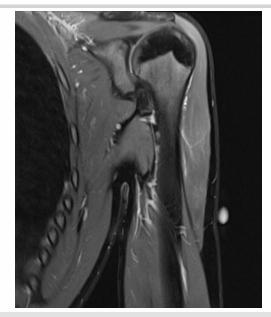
A sequential coronal magnetic resonance imaging slice following resolution of symptoms showing a reduction in the observed level of edema within the deltoid.
